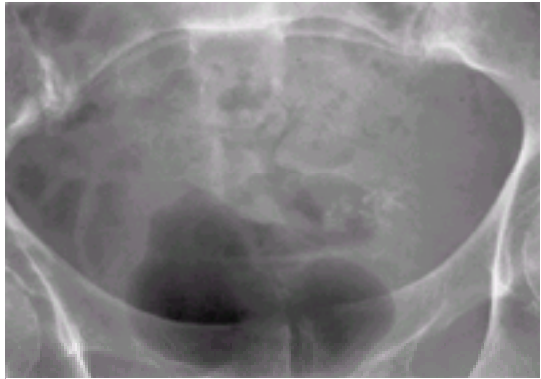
Plain film of the pelvic outlet showing amorphous calcific deposits on a papillary transitional-cell tumour in the bladder.
